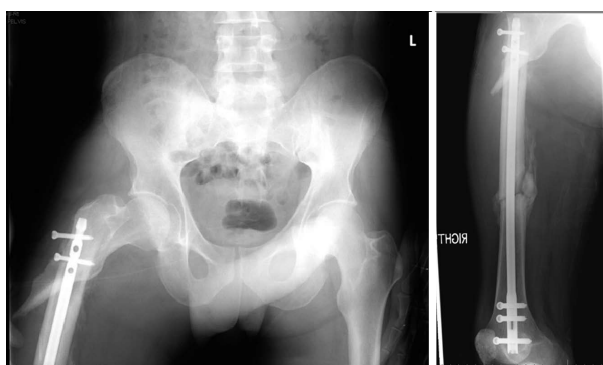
Anteroposterior and lateral radiographs of right femur showing peri-implant fracture involving the Interlocking screw site in the subtrochanteric area. Also seen is the femoral shaft fracture with interval healing.
